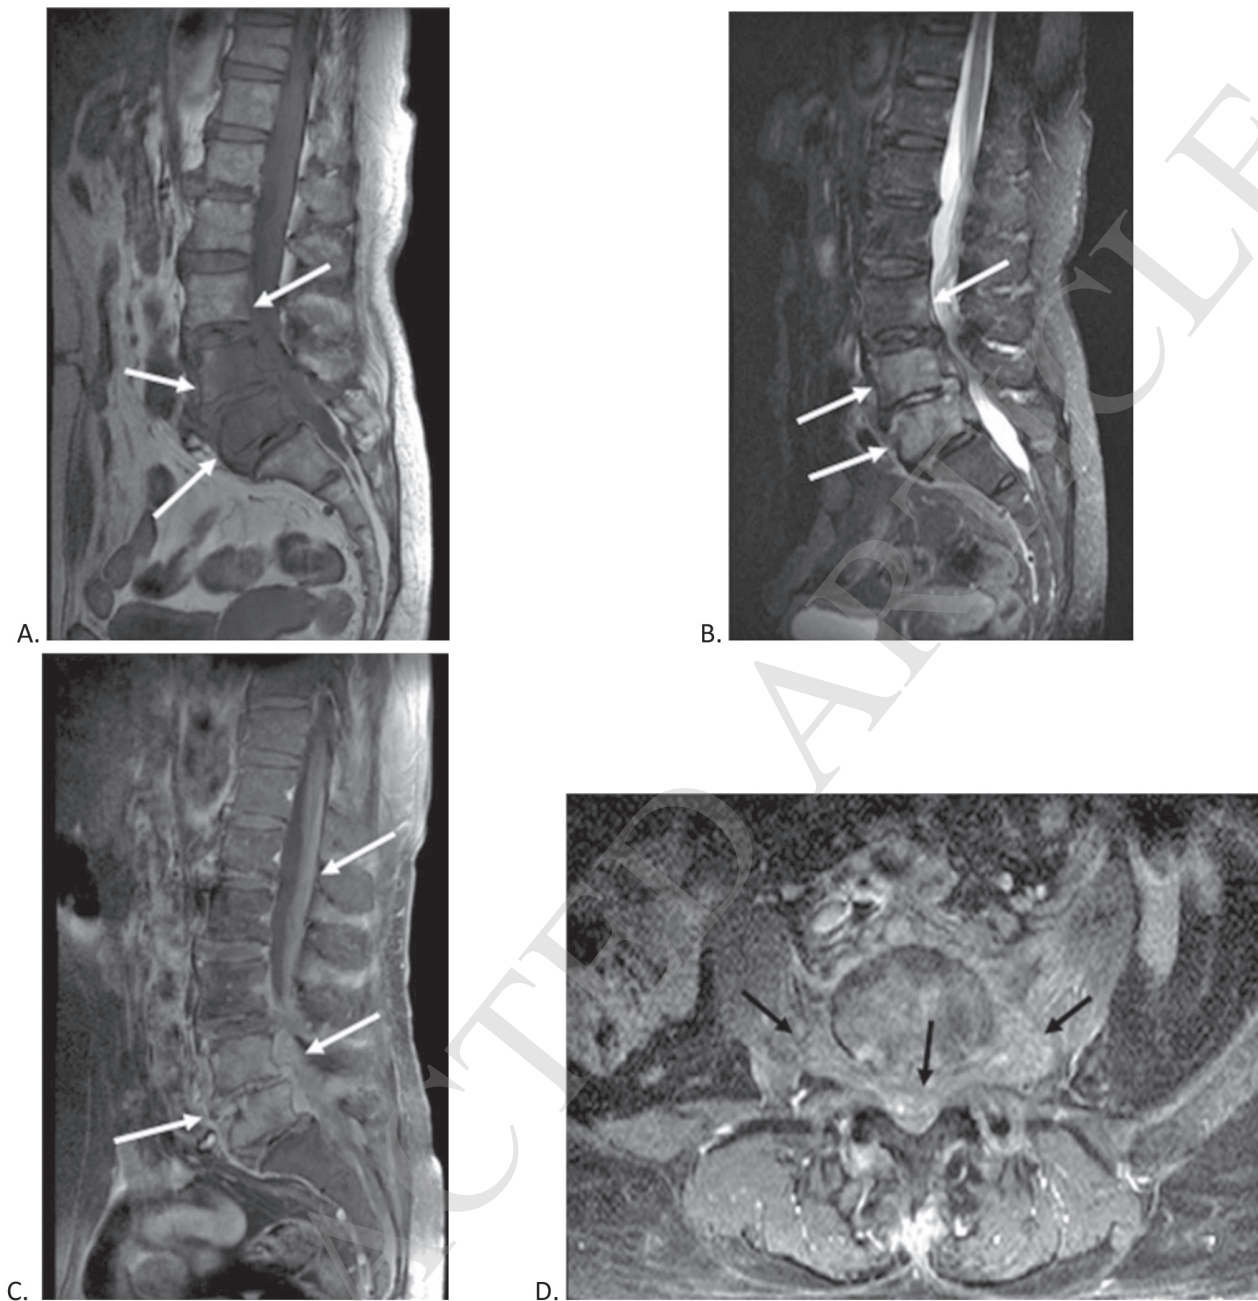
Pyogenic spondylodiscitis. A 73-year-old woman with back pain and mild weakness of both legs for 1 month. A. T1- weighted sagittal MRI shows diffuse T1 hypointensity (white arrows) in the L4 and L5 vertebral bodies as well as some in the posterior aspect of L3 vertebral body. B. T2-weighted, fat-saturated sagittal MRI demonstrates abnormal T2 hyperintensity in the narrowed L4-5 disc space (white arrows) and T2 hyperintensity in the L4 and L5 vertebral bodies as well as some in the posterior aspect of L3 vertebral body (white arrows). C. Postgadolinium, fat-saturated T1-weighted sagittal MRI reveals marrow enhancement corresponding to the abnormal vertebral marrow signal. Evidence of disc enhancement, enhancing ventral epidural soft tissue, and thin anterior paraspinal enhancement extending from lower L3 to upper S1 level (white arrows) is seen. Enhancing cauda equina nerve roots are also seen, indicating radiculitis/arachnoiditis. Note a small nonenhancing portion in the anterior paravertebral region at the upper L5 level, representing small abscess formation. D. Postgadolinium, fat-saturated T1-weighted axial MRI confirms the vertebral marrow enhancement, enhancing ventral epidural and paraspinal soft tissue (black arrows). The blood cultures were positive for *S. aureus*, and then she was treated for pyogenic spondylodiscitis with antibiotics.
